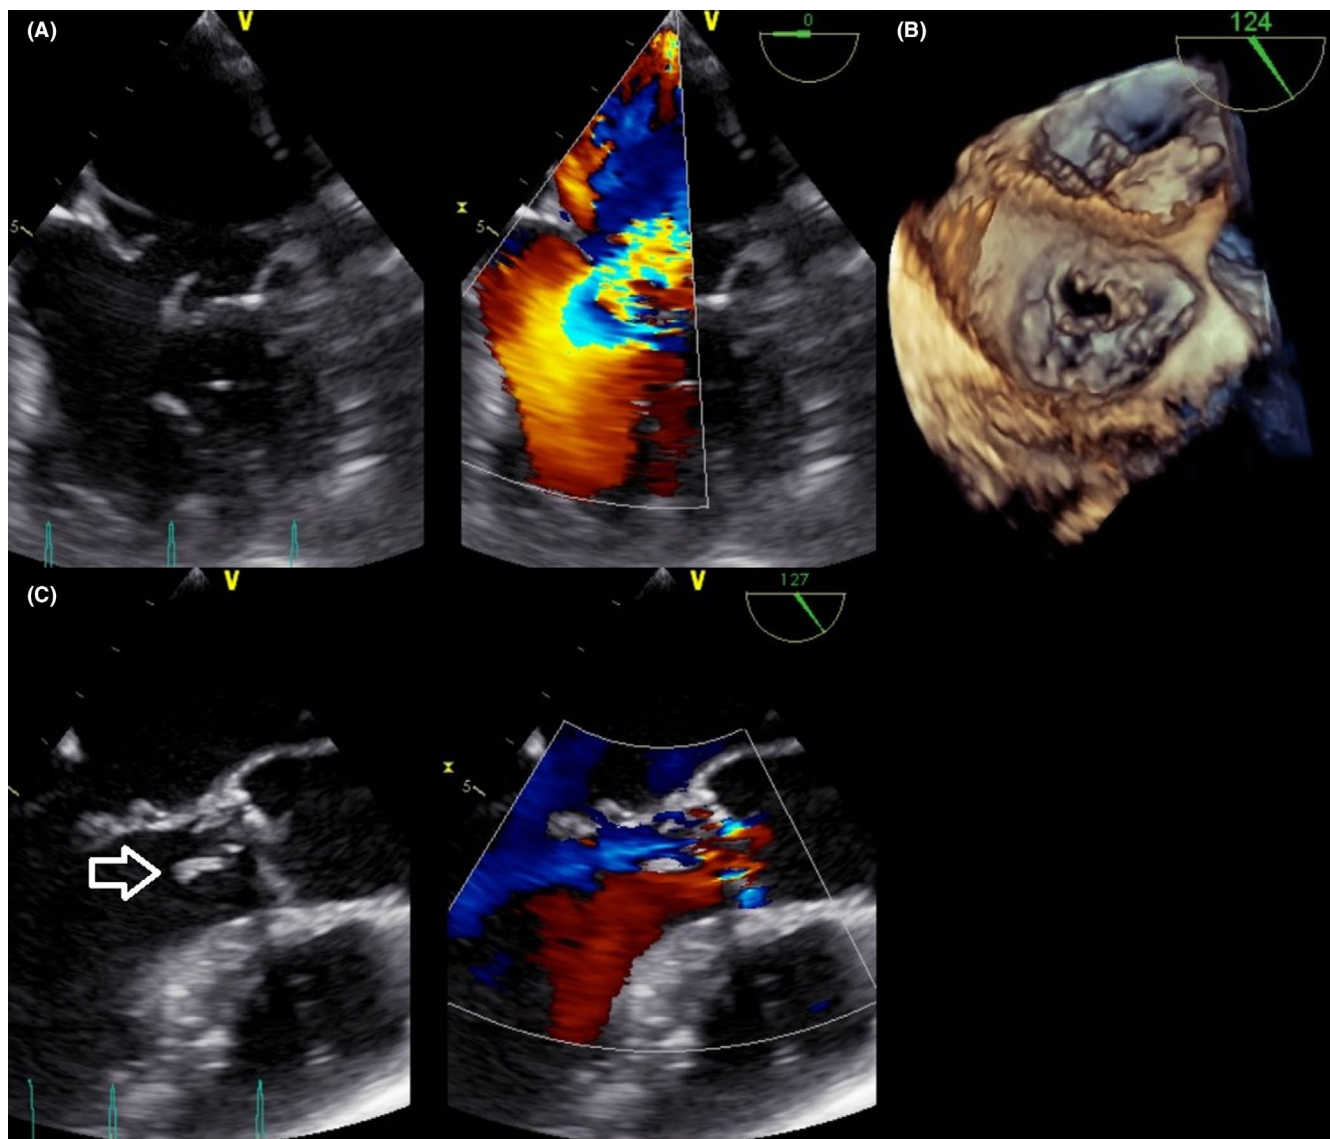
Panel A. 9-mm defect of the AMVL due to perforation seen by 2D TEE from the apical 4-chamber view. Panel B. Perforated AMVL seen by 3D TEE in the “surgeon’s view.” Panel C. Mobile vegetation attached to the right aortic cusp and prolapsing toward the left ventricle with a moderate aortic regurgitation
